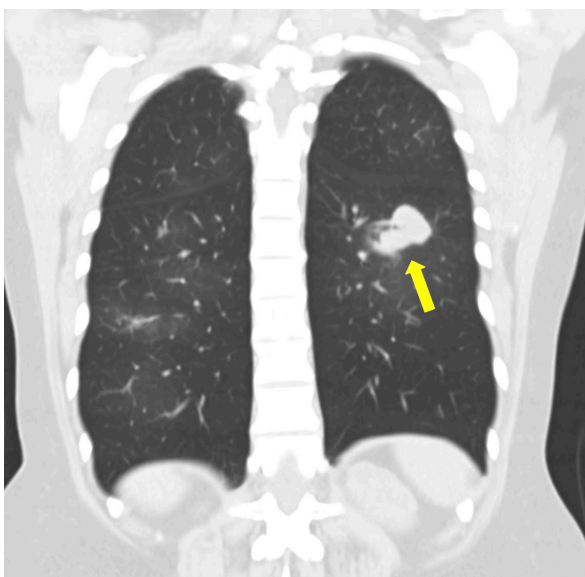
CT Chest: Coronal view of 3.8 cm nodule.
